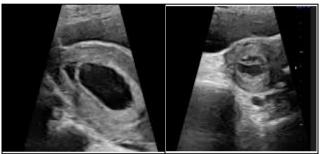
Ultrasonography Images Depicting Focal Sub-Chorionic Collection in an Ongoing Pregnancy with Gestational Age of 8 Weeks
